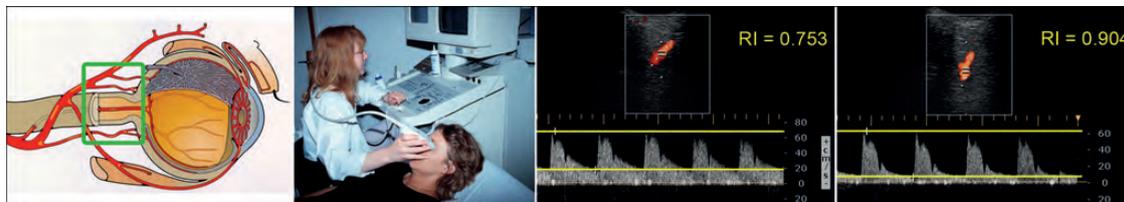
The vessels behind the eye (ophthalmic artery, central retinal artery, and the ciliary arteries) can be visualized and its flow quantified by colour Doppler imaging. Shown is the outcome from the ophthalmic artery of a healthy subject with normal resistivity (middle) and of a glaucoma patient with high resistivity (right). (Modified after Flammer J, Mozaffarieh M, Bebie H. *Basic Sciences in Ophthalmology—Physics and Chemistry*. Springer Publications, in print, with permission.)
